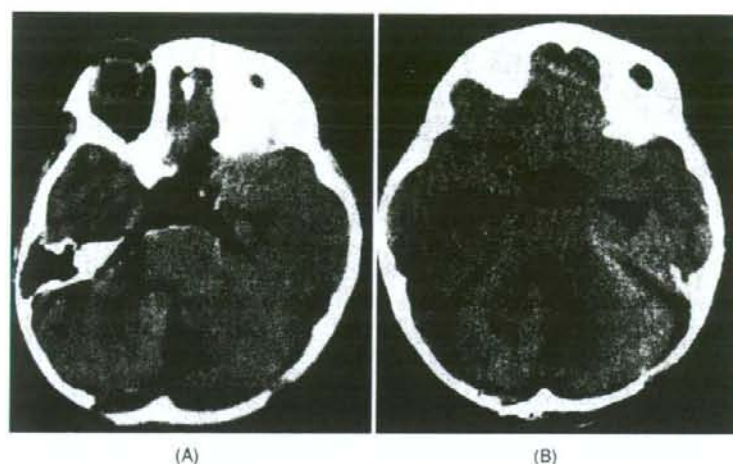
Representative unenhanced CT scan of a CO<sub>2</sub>-treated patient immediately after surgery, showing accumulation of gas in ventricles and subdural spaces (A), and 1 day later showing complete disappearance of the gaseous body (B).
